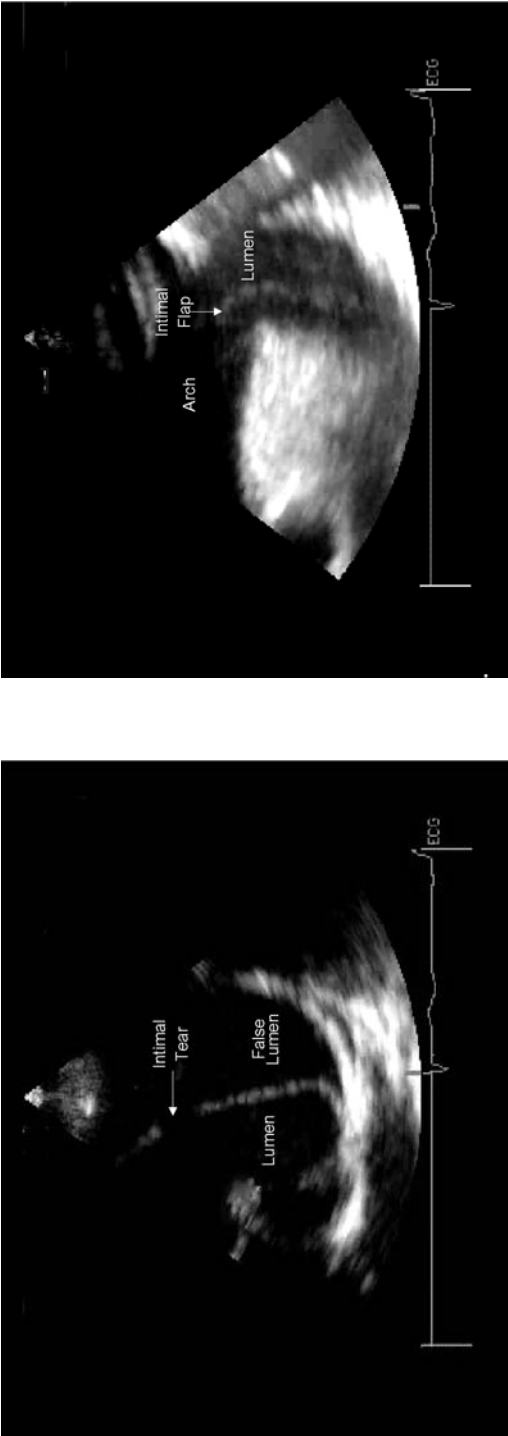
(Continued) (c) The aorta is still dilated at the level of the arch. An intimal flap is present along the posterior wall of the arch (arrows). (d) The responsible tear was in the distal arch and can be seen on this transthoracic view as a (PISA) proximal isovelocity surface area (arrows).
